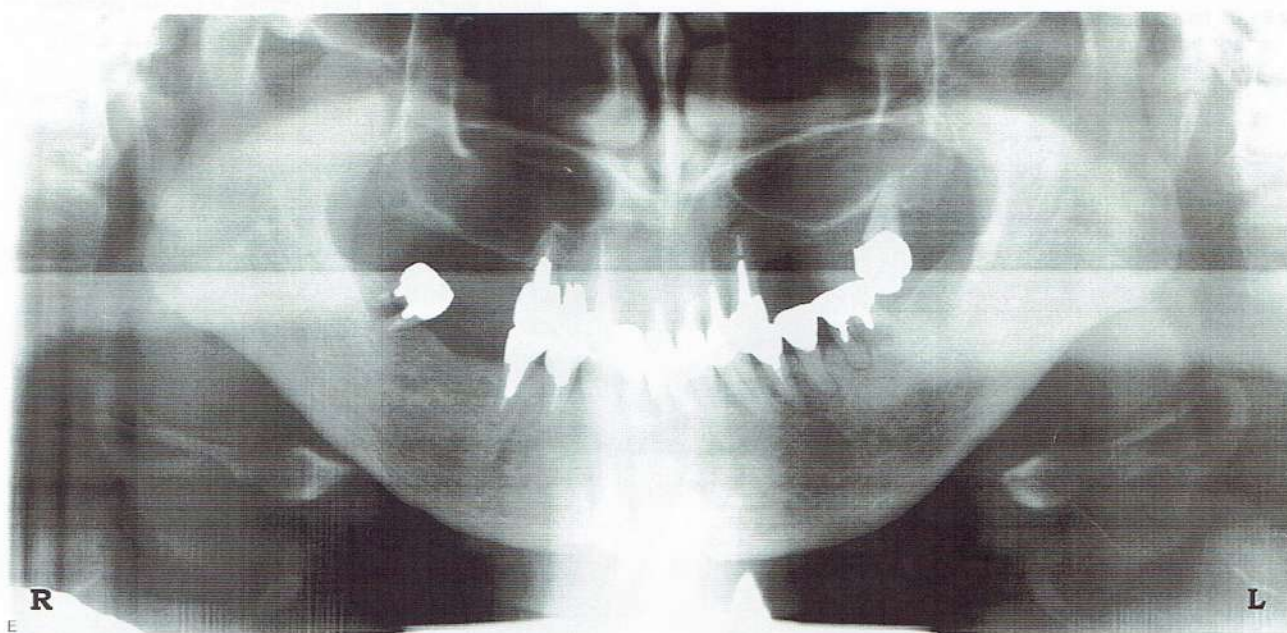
Preoperative radiograph (Case 2) showing the pneumatization of maxillary sinus and atrophy of the alveolar ridge
